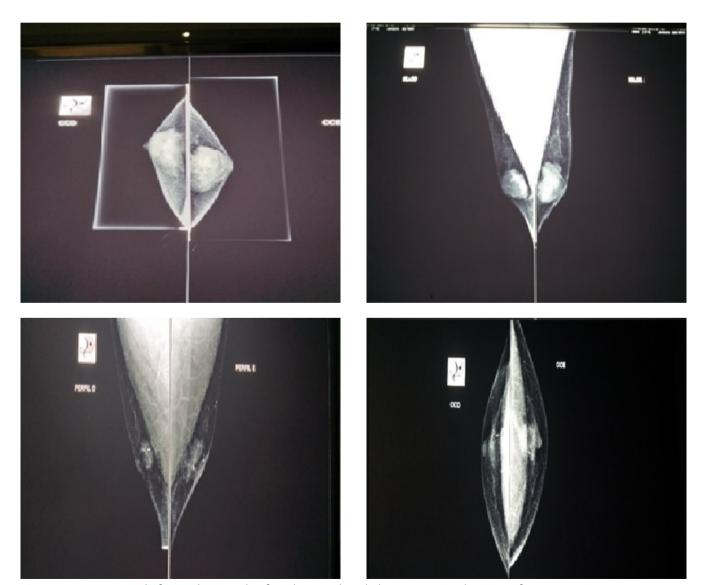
Mammograms before and six months after ultrasound-guided vacuum-assisted excision of gynecomastia.
